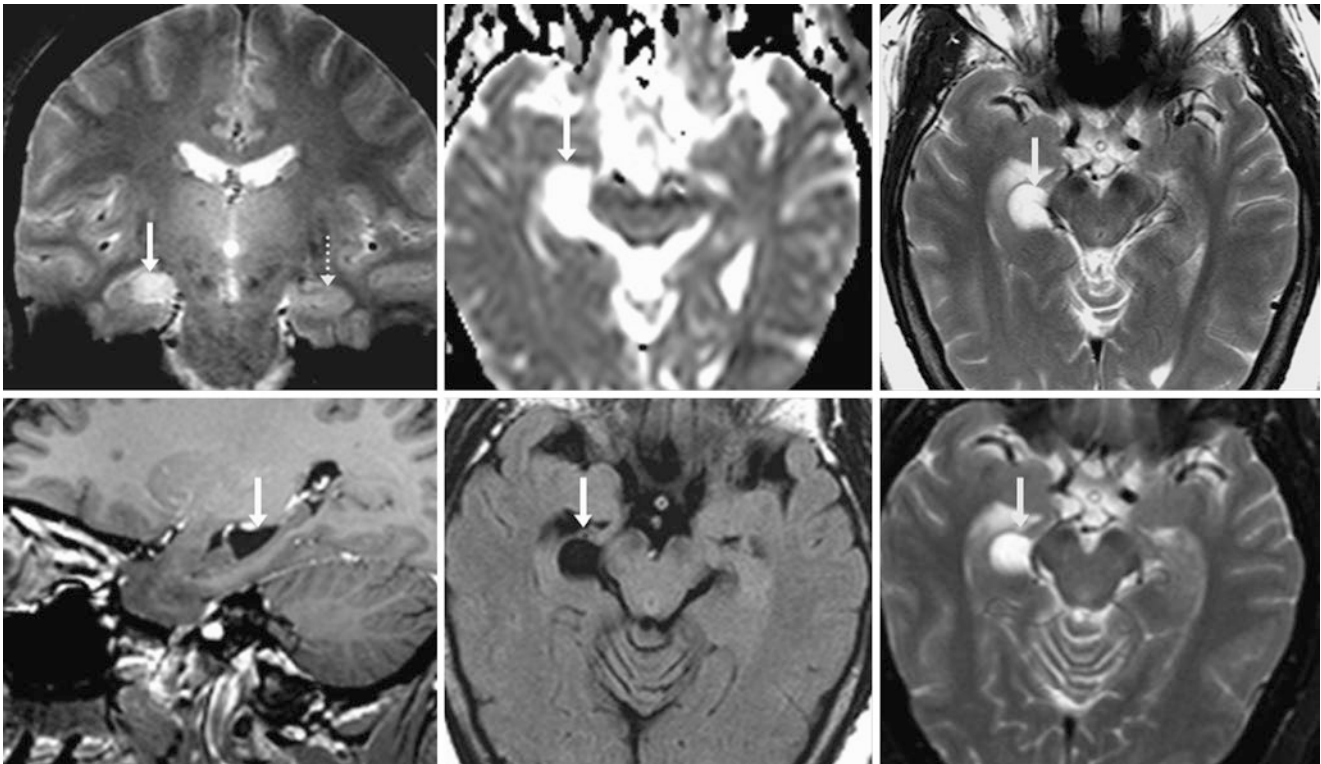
A 59-year-old with a 3 T MRI of a CFC (*arrows*) that mimics edema from mesial temporal sclerosis on coronal T2*WI (*top left*). The cyst has high diffusivity on an ADC map (*top middle*) and is bright on T2WI (*top right*). A sagittal postcontrast T1WI (*bottom left*) depicts how the cyst mildly displaces adjacent structures. On a 1.5 T MRI from 10 years earlier, the cyst appeared the same on FLAIR (*bottom middle*) and T2WI (*bottom right*)
